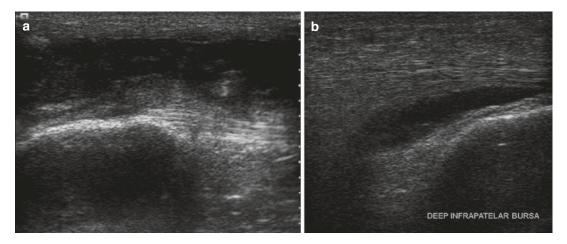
(a, b) Chronic frictional prepatellar and infrapatellar bursitis in two different patients: (a) ultrasound longitudinal section of prepatellar bursa; (b) ultrasound longitudinal image of the deep infrapatellar bursa. In the first patient, a hypoechoic structure with thick irregular wall and internal hyperechoic debris is seen within
